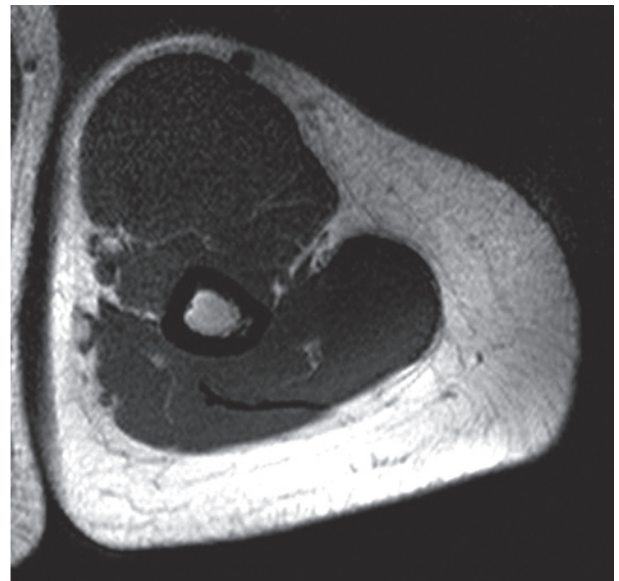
Magnetic resonance imaging revealed marked, symmetrical accumulation of subcutaneous fatty masses in the left proximal upper extremity.
